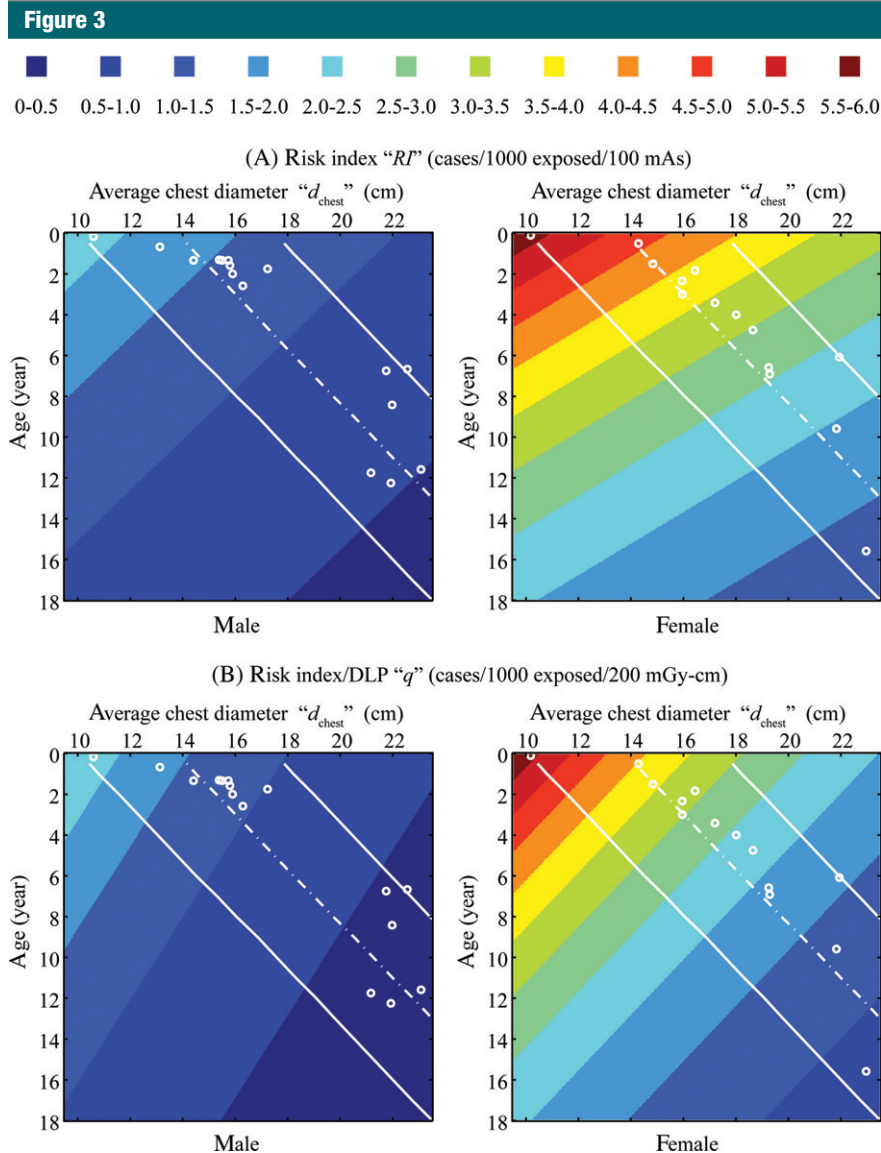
Top: Risk index (RI), associated with protocol A, as a function of patient age and average chest diameter (d_{chest}). Plotted risk index values were generated by using $RI(d_{\text{chest}}, \text{age}) = \exp(\alpha_{RI} d_{\text{chest}} + \beta_{RI} \text{age} + \gamma_{RI})$ with fitting parameters α_{RI} , β_{RI} , γ_{RI} for protocol A (Table 4). Bottom: Risk index normalized by DLP (q), associated with protocol A, as a function of patient age and average chest diameter. Plotted q values were generated using $q(d_{\text{chest}}, \text{age}) = \exp(\alpha_q d_{\text{chest}} + \beta_q \text{age} + \gamma_q)$ with fitting parameters α_q , β_q , γ_q for protocol A (Table 4). The unit of cases per 1000 cases per 200 mGy \cdot cm was chosen such that the values in the top and bottom plots have a similar range. Dotted lines = mean chest diameter (and its 95% prediction interval [solid lines]) at each age calculated by using published thorax size data for pediatric CT patients (30). \circ = ages and average chest diameters of the 30 patients in this study.
